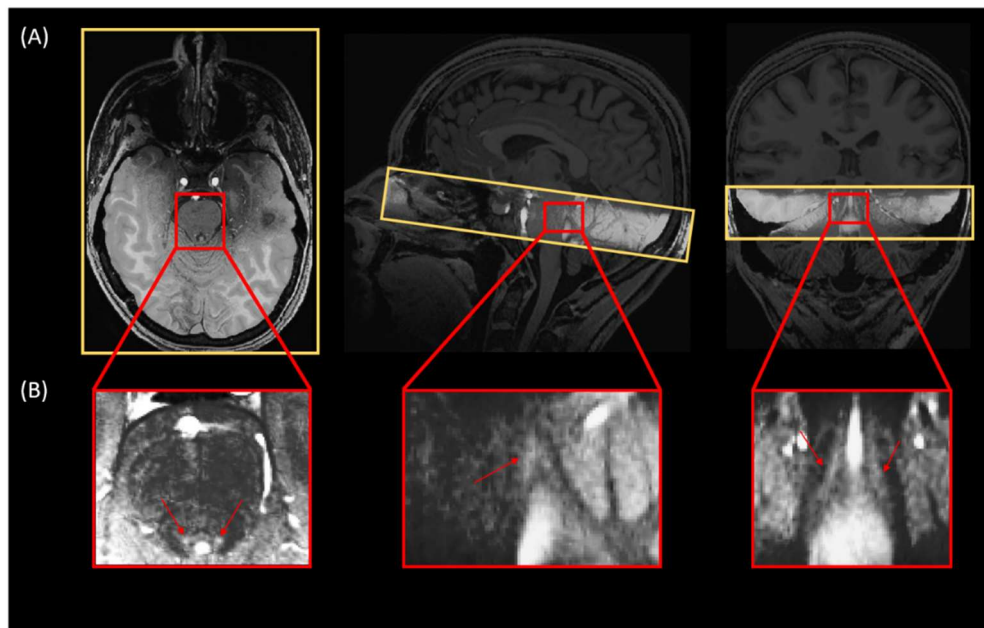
(A) Realigned LC slab on the anatomical T1-weighted image and (B) LC hyperintensity on the MT-TFL image.
